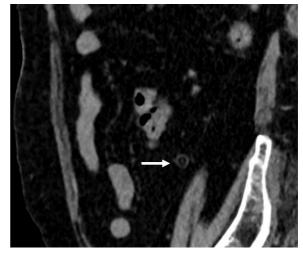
Non-contrast Enhanced Computed Tomography sagittal plane
